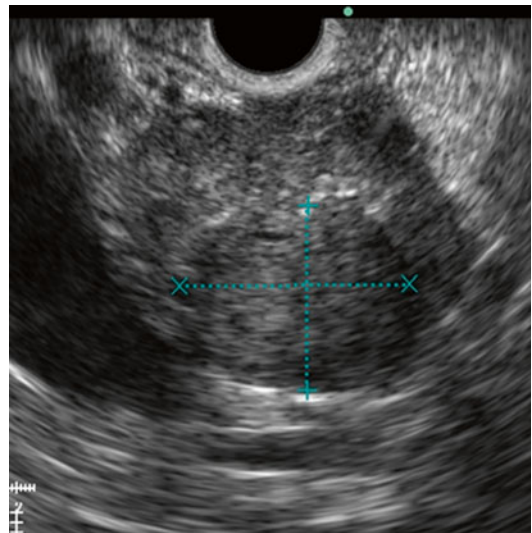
There was a hypoechoic area measuring approximately 20 mm × 17 mm inside the mass. Endosonographically, it showed a well-defined border, it was encapsulated, and hypoechoic solid lesions showed an irregular margin. A deep hypoechoic area was observed inside the mass, likely the beginning of cystic degeneration of the mass. This area was not detected in a CT scan, reflecting the superiority of EUS over CT. No vessel invasion was observed. No lymph node was observed
